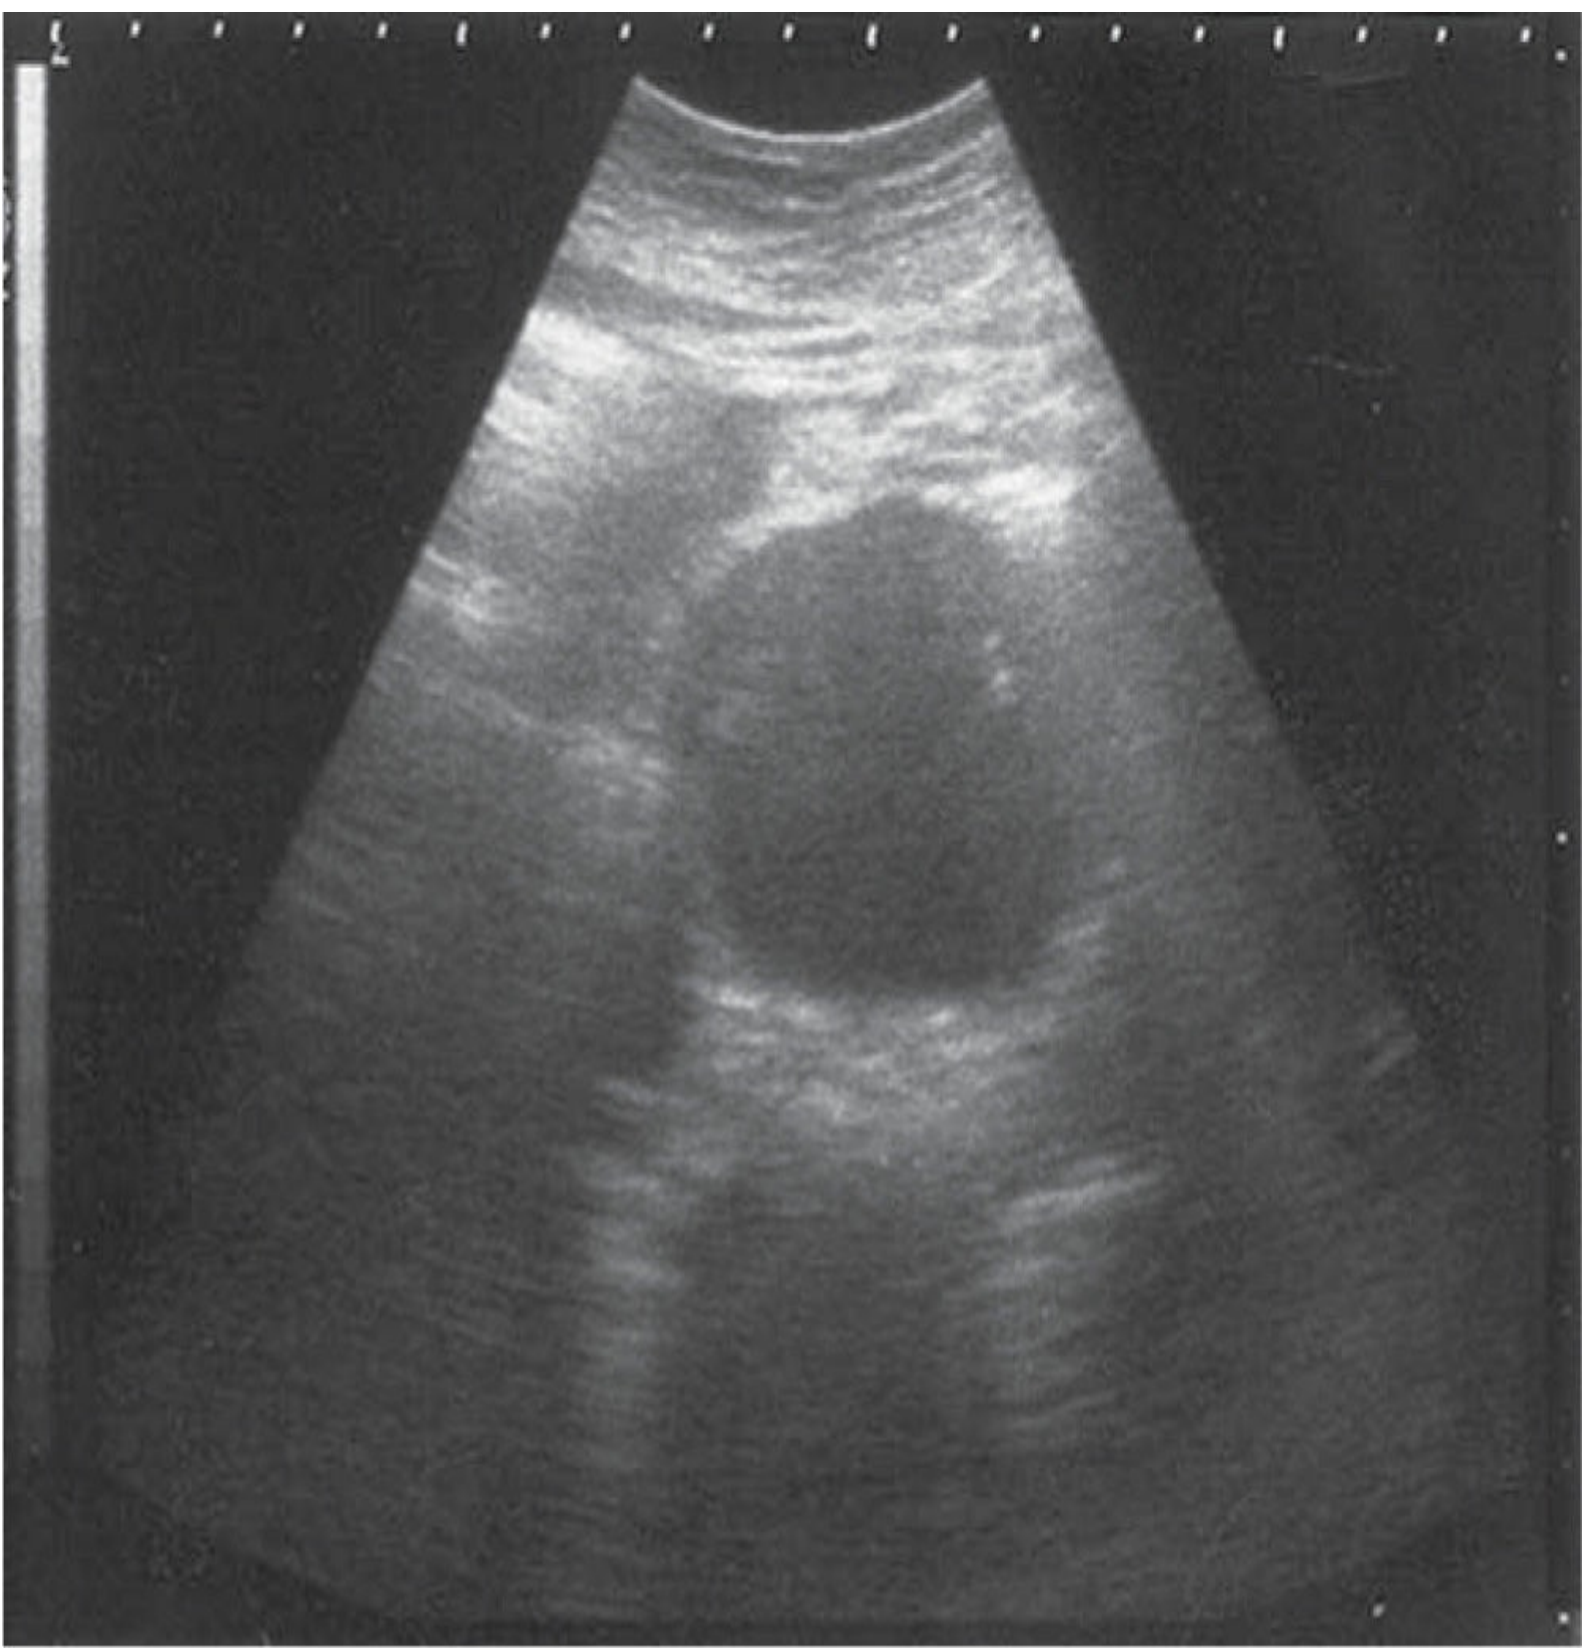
Ultrasound image of an abdominal aortic aneurysm in the transverse plane. (Reproduced, with permission, from Tintinalli JE, Stapczynski J, Ma O, et al, eds. *Tintinalli's Emergency Medicine: A Comprehensive Study Guide*. 7th ed. New York: McGraw-Hill; 2011.)
